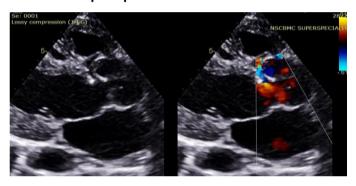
Preoperative ECHO (parasternal long axis view) showing prolapse of right coronary cusp into VSD leading to restricted shunt
